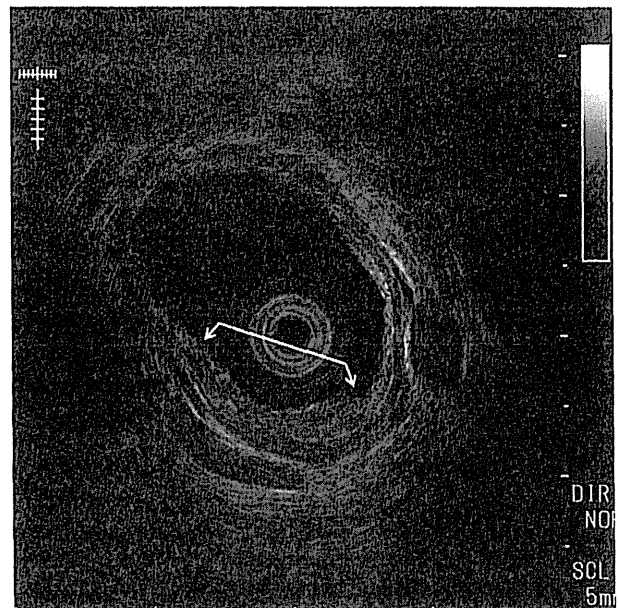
Endoscopic ultrasonography (EUS) image demonstrates a low echoic mass located in the submucosal layer (arrow).
